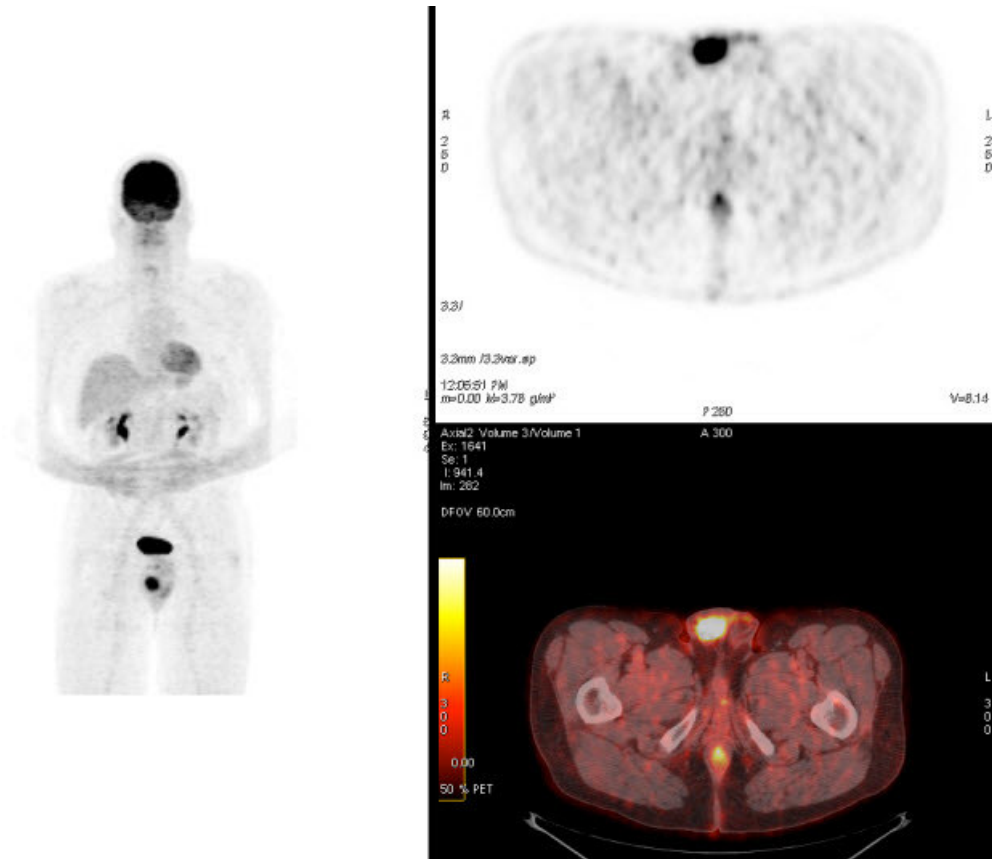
51 year old male with diffuse large B-cell non-Hodgkin's lymphoma. Coronal MIP, axial PET and axial fused PET/CT performed 11 months after initial chest CT at the level of the testicles after intravenous administration of 15.965 mCi of FDG demonstrating isolated relapse within the right testicle with SUVmax now of 12.4.
